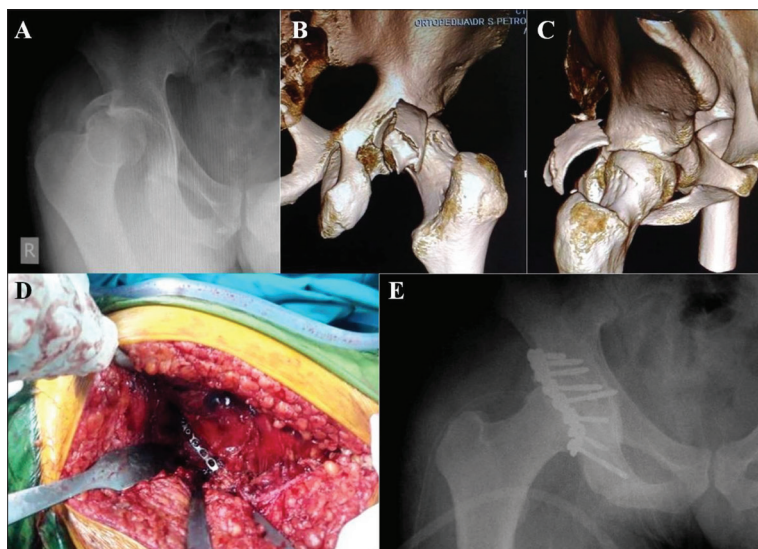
Open reduction and internal fixation of acetabular fracture-dislocation; A: X-ray after the injury; B, C: 3D computed tomography scan after reduction of dislocated femoral head shows a dislocated posterior wall acetabular fracture; D: intraoperative view after fracture fixation by Kocher–Langenbeck surgical approach; E: X-ray after the surgery
